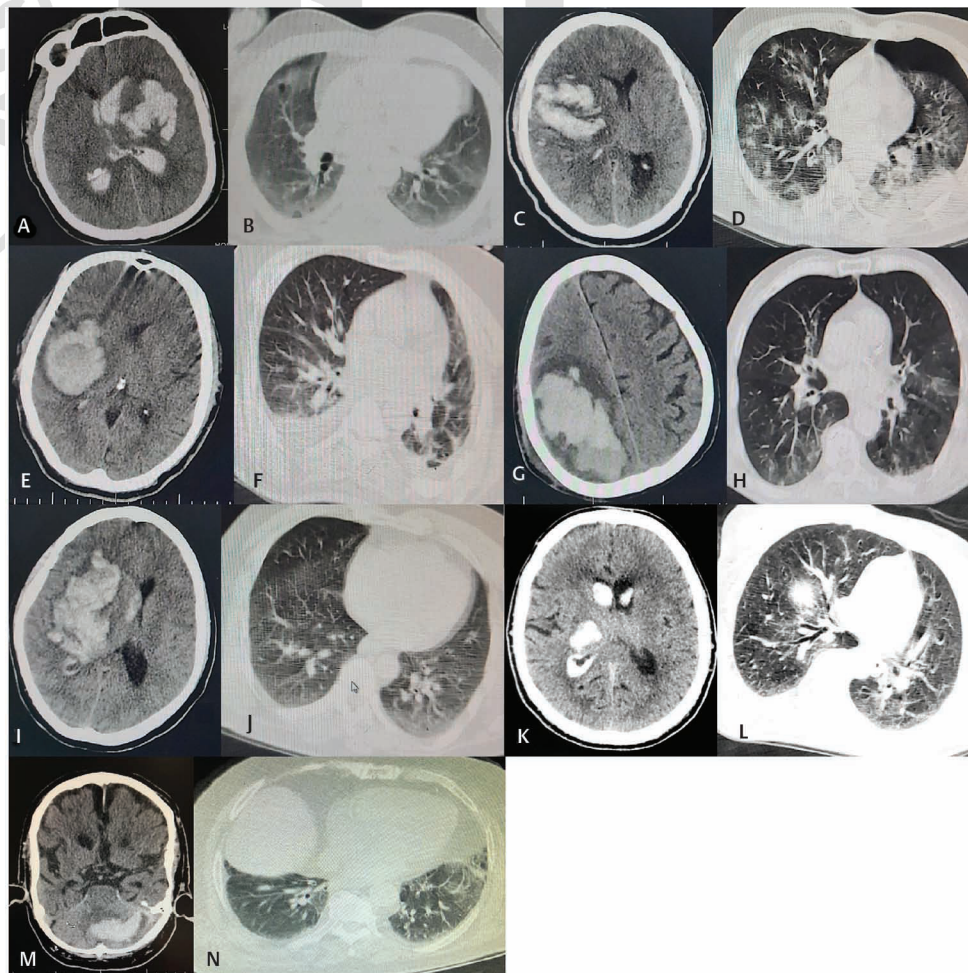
Axial brain (A, C, E, G, I, K, and M) and chest computed tomography (B, D, F, H, J, L, and N) scan of the patients showing intracerebral hemorrhage along with the pattern of pulmonary involvement by coronavirus disease 2019 (patient no. 1: A and B; patient no. 2: C and D; patient no. 3: E and F; patient no. 4: G and H; patient no. 5: I and J; patient no. 6: K and L; patient no. 7: M and N).
